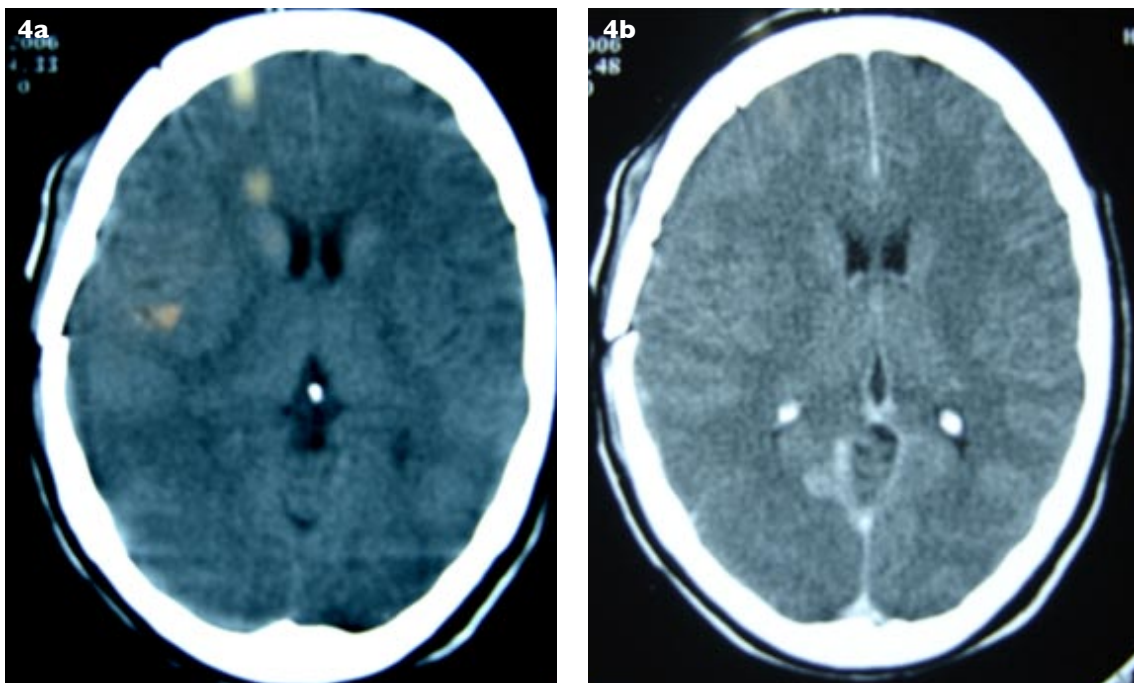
Post-craniotomy (a) pre- and (b) post-enhancement axial CT images show the contrast enhancement along the right side of the tentorial hiatus with a nodule.
